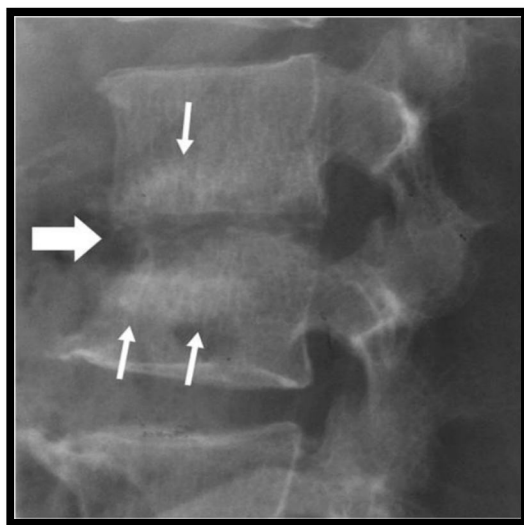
Severe tuberculous spondylodiscitis. Lateral lumbar spine radiograph shows destruction of the L2-L3 intervertebral disc and adjacent vertebral bodies (thick white arrow), with adjacent bone sclerosis (thin white arrows)[40].
